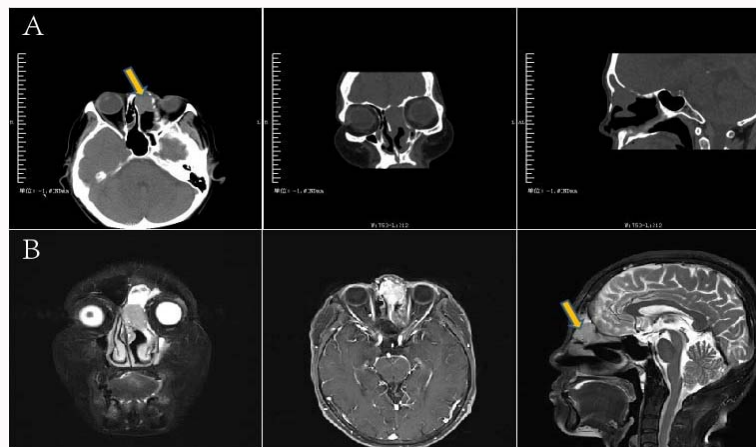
A: Soft tissue density shadow in the left frontal sinus and ethmoid sinus was visible (Yellow arrow), and the adjacent bone resorption became thinner and the structure was irregular (CT). B: After the operation of left ethmoid sinus, soft tissue mass shadow was observed in the left ethmoid sinus (Yellow arrow), with homogeneous signal, T1 equal signal, T2 slightly high signal, DWI high signal and ADC low signal. The mass was significantly enhanced after enhanced scanning (MRI).
